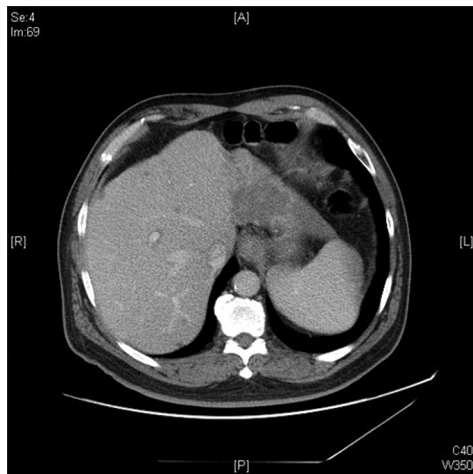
Follow-up computed tomography scan revealed only few residual tumors seen in the right liver on February 22, 2021
